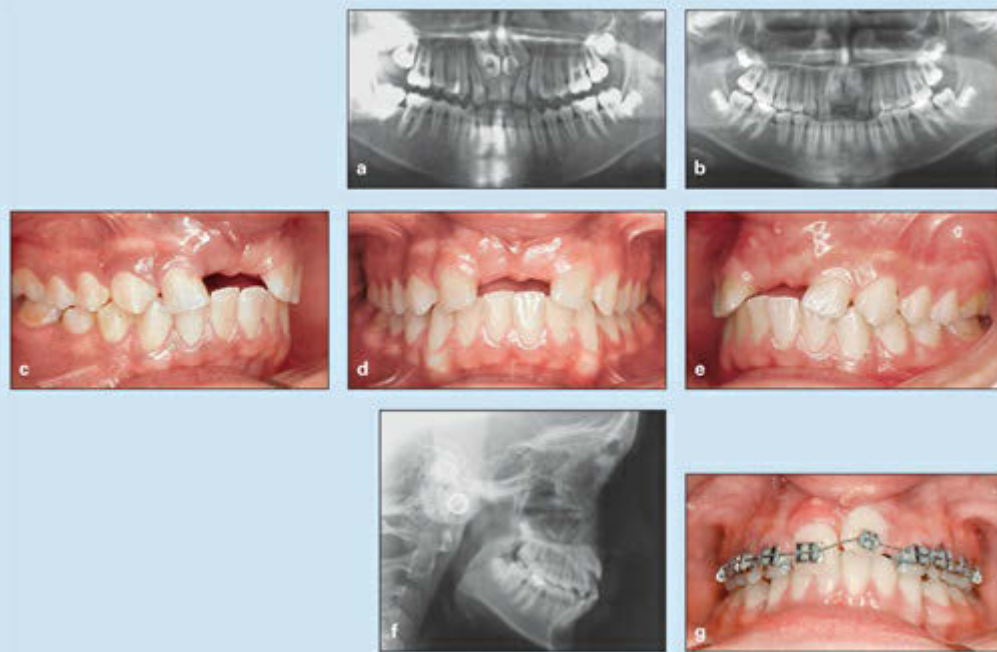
Treatment of a 14-year, 6-month-old girl with unerupted maxillary central incisors. (a) Panoramic radiograph taken by a dentist 2 years before orthodontic referral. (b) Panoramic radiograph taken after extraction of both mesiodentes and before orthodontic treatment. (c to e) Pretreatment occlusion. (f) Pretreatment lateral cephalometric radiograph revealing anterior crowding and severe dental protrusion. (g) Orthodontic traction of the central incisors.
